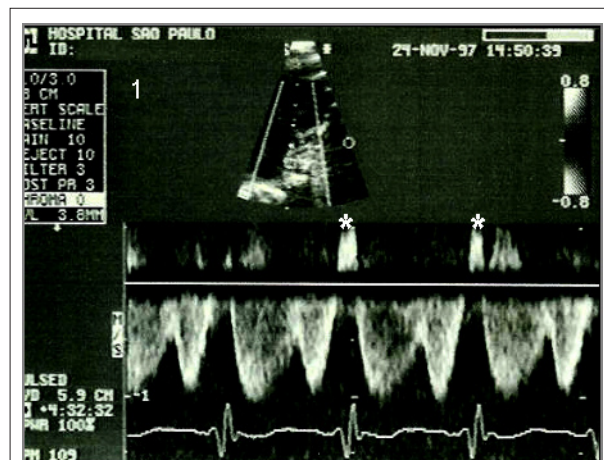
Echocardiograph image showing continuous pulmonary venous flow, with systolic and diastolic waveforms of equal amplitude and the reversed atrial contraction pattern.
